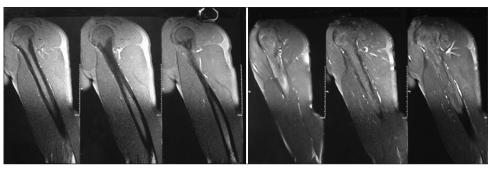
MRI right arm showing thickened cortex with altered signal intensity involving the right humerus head and proximal shaft
